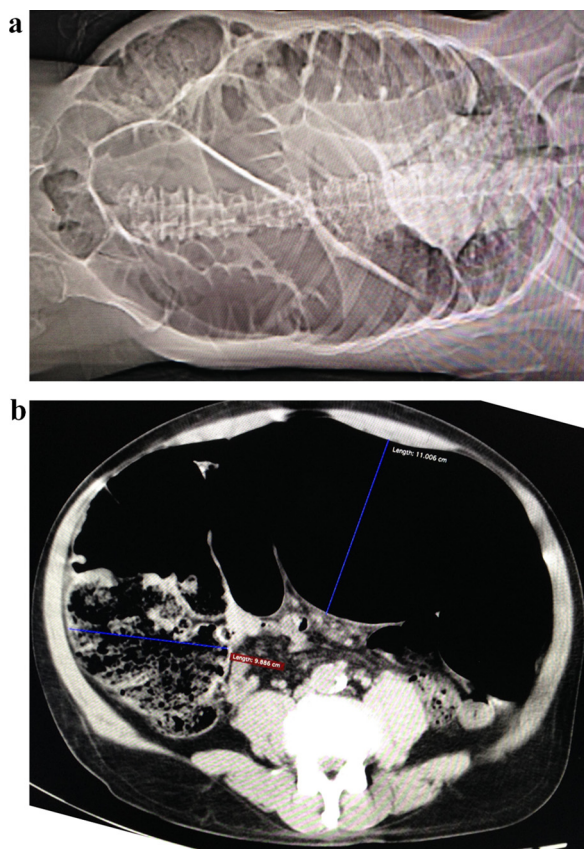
A&B: CT ski gram (A) and cross section view (B) of abdomen demonstrating the Steel pan sign.
